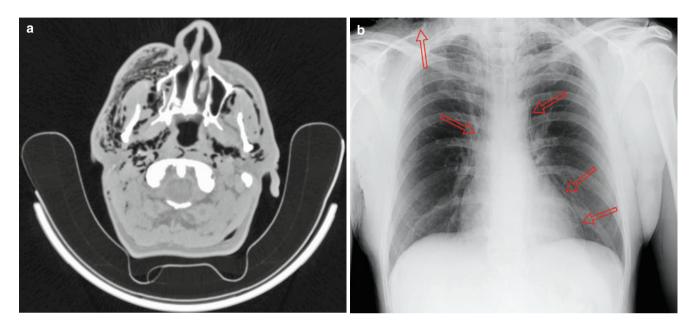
Extensive surgical emphysema in a patient who repeatedly blew their nose following injury. In view of its extent, a chest radiograph was requested. This showed subcutaneous and mediastinal extension with "streaking" and outlining of the pericardium (silhouette sign) (a, b)
